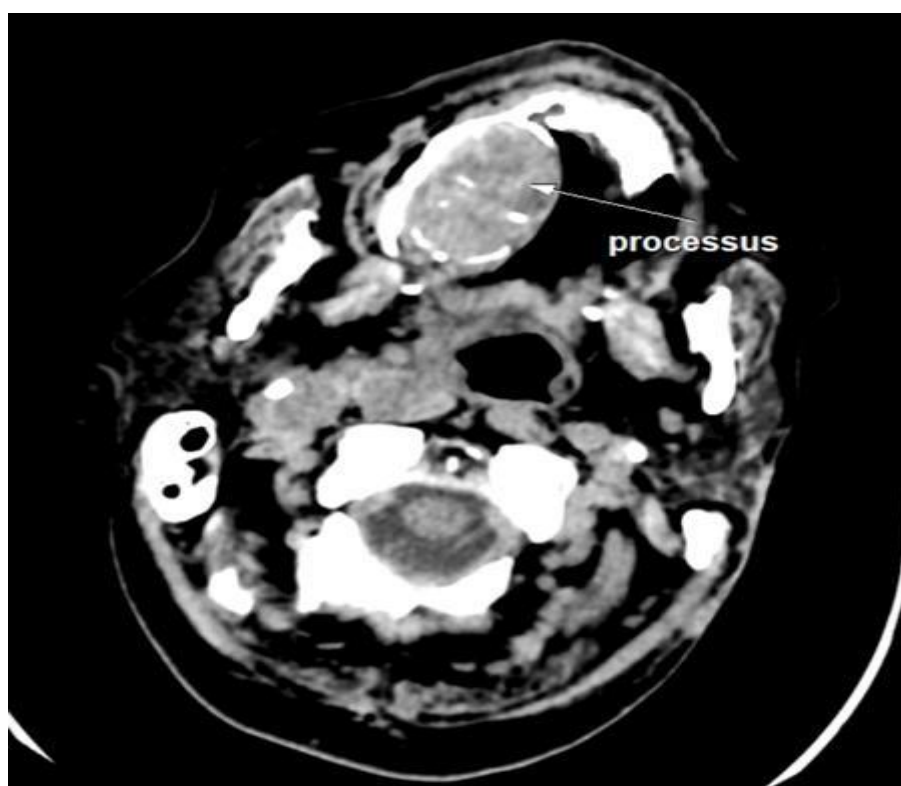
Axial CT scan of the paranasal sinuses demonstrating extension of a tumor mass into adjacent structures.
